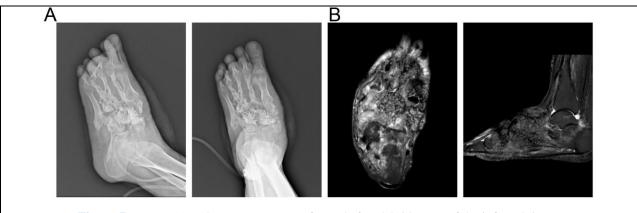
X-ray (A) and MRI (B) were performed after debridement of the infected tissue.
